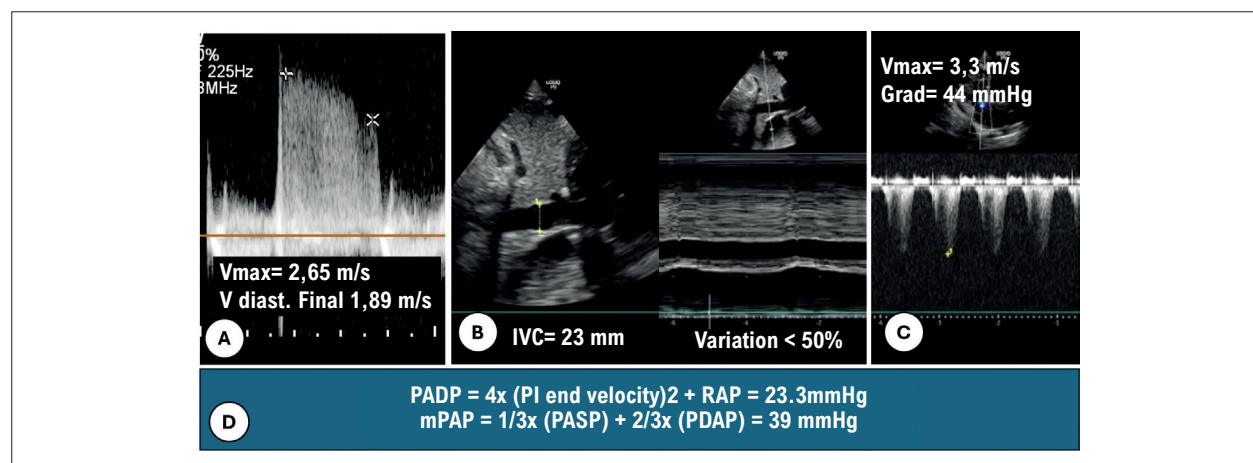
Estimation of mPAP and pulmonary artery diastolic pressure (PADP) using the initial and final velocities of pulmonary insufficiency (PI): A) PI on continuous-wave Doppler; mPAP is obtained by summing RAP with the peak gradient of PI calculated using the Bernoulli equation. PADP is obtained by calculating the gradient considering the end-diastolic velocity of PI added to RAP; B) Estimation of RAP by evaluating the IVC and its respiratory collapsibility; C) TR; D) Application of formulas for calculating mPAP and PADP; PASP: pulmonary artery systolic pressure; IVC: inferior vena cava.
